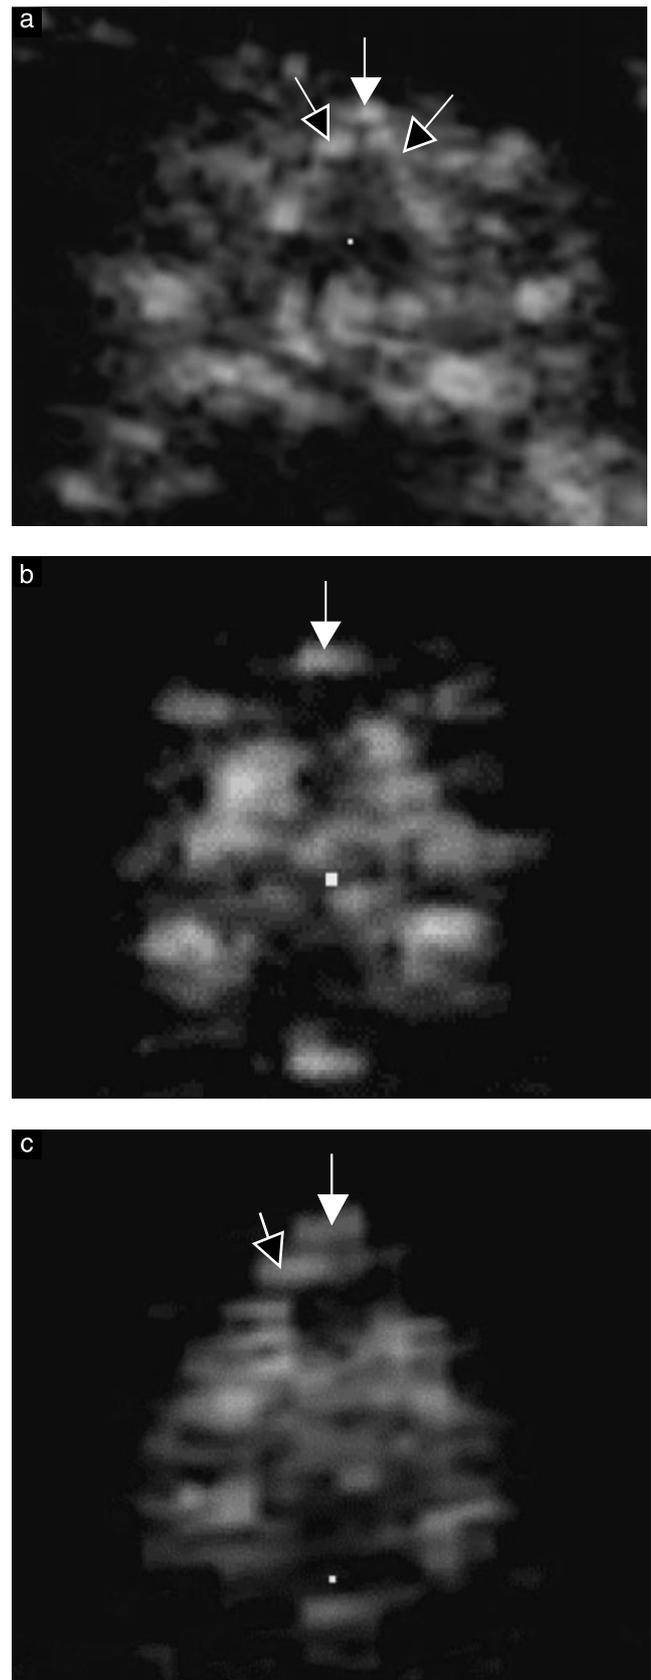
Transverse views of the fetal nasal bones in the multiplanar mode of three-dimensional ultrasound. In (a) there is a small gap between the nasal bones, in (b) there is absence of both nasal bones and in (c) there is absence of one of the nasal bones. White arrows, skin; black arrows, nasal bone.
